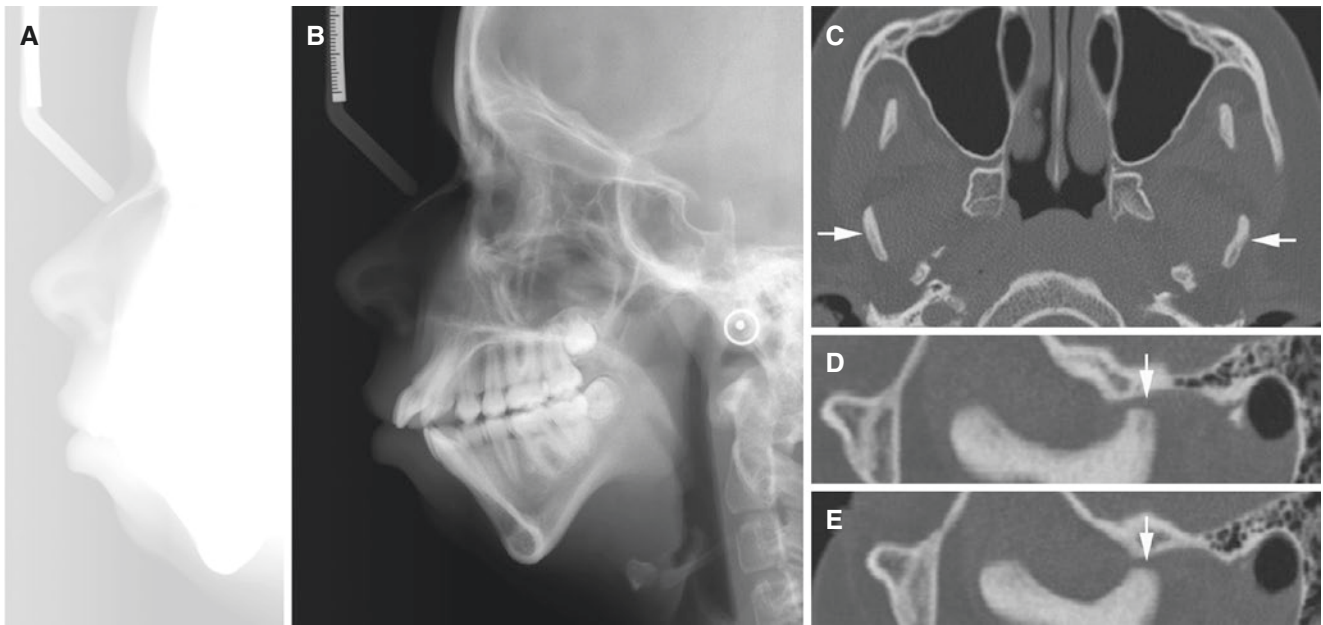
Juvenile idiopathic arthritis, micrognathia; 13-year-old female. (A) Lateral view, soft-tissue profile, and (B) lateral view, bone profile, show micrognathia (retruded chin). (C) Axial CT image shows abnormal long axis angulation of both condyles (arrows) and very thin
